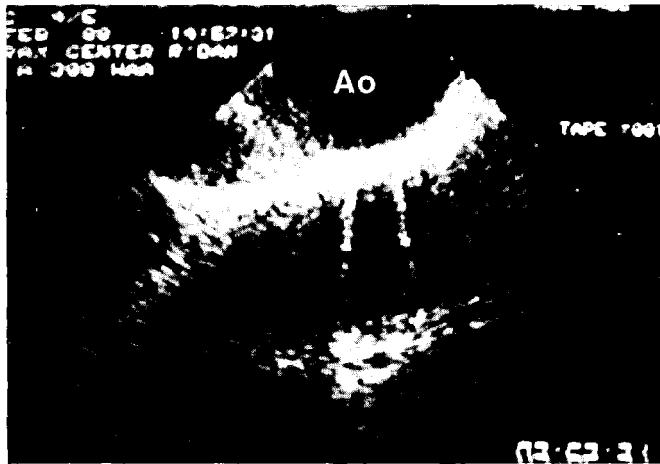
Transthoracic two-dimensional echocardiographic cross-section through the descending thoracic aorta (Ao) at the level of the aortic arch.
